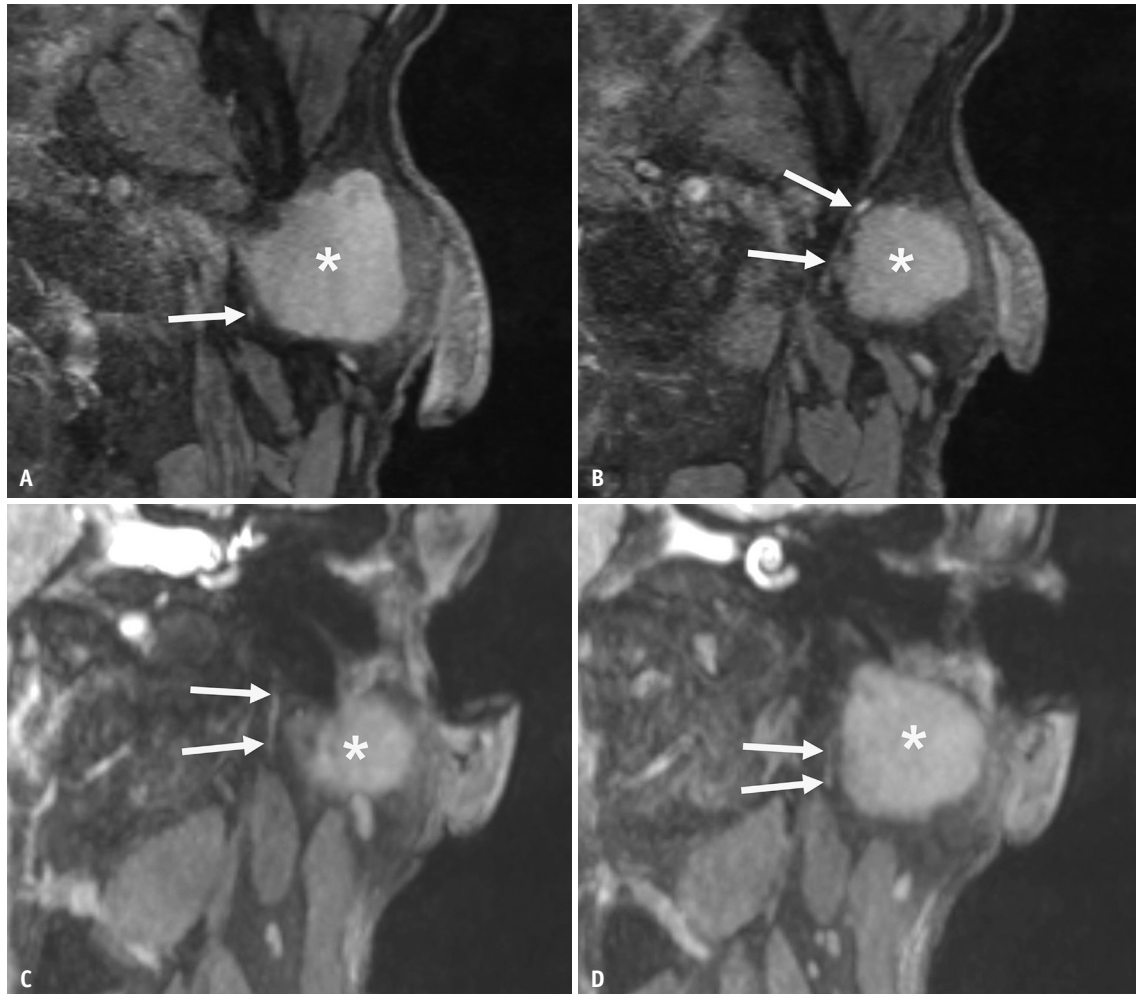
Representative images of 3D-DESS-WE-MRI in a case with a left parotid gland tumor (pleomorphic adenoma). A, B: Serial axial scans. C, D: coronal scans. The arrows indicate the main trunk (A, C) or the cervicofacial branch (B, D) of the intra-parotid facial nerve. Asterisks indicate tumor. 3D-DESS-WE-MRI = three-dimensional double-echo steady-state water-excitation sequence magnetic resonance imaging
